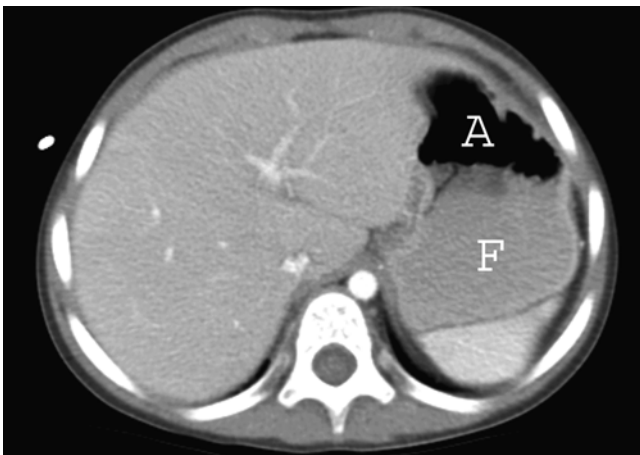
CT of the abdomen without administration of oral contrast in a fasting 2-year-old child in supine position. CT shown in axial (A) plane. Note fluid (labeled “F”) and air (Labeled “A”) in distended stomach. Measured volume of fluid in stomach was 41.8 mL (3.3 mL/kg). Courtesy of Mohamed Mahmoud, MD
